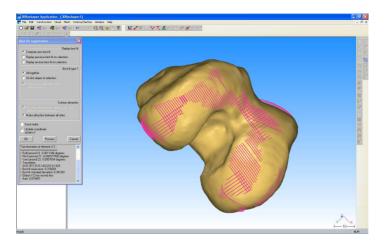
Knee-joint - the imposition of measuring points from CMM on the surface obtained from measurements on CT using the "best fit" method.
